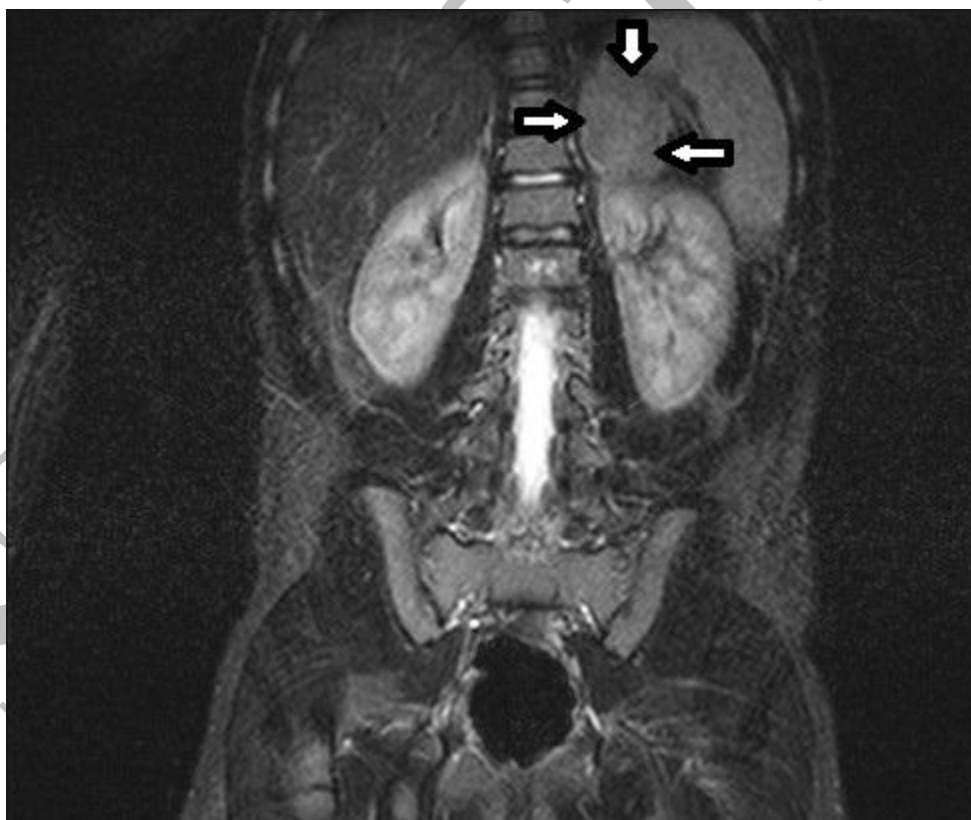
MRI abdomen showing left adrenal adenoma
